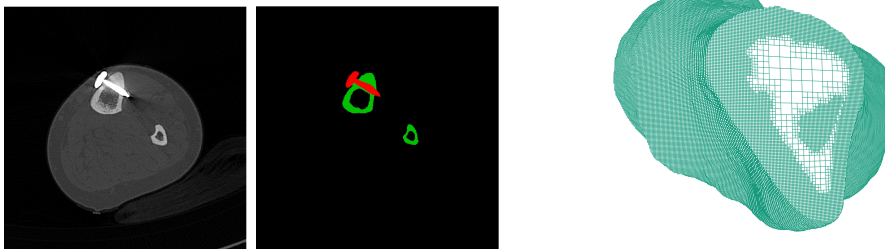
Individual slice of the original computed tomography image (left); results of the segmentation process of the same slice (middle); cut through the octree based volume mesh with hanging nodes structure (right).
